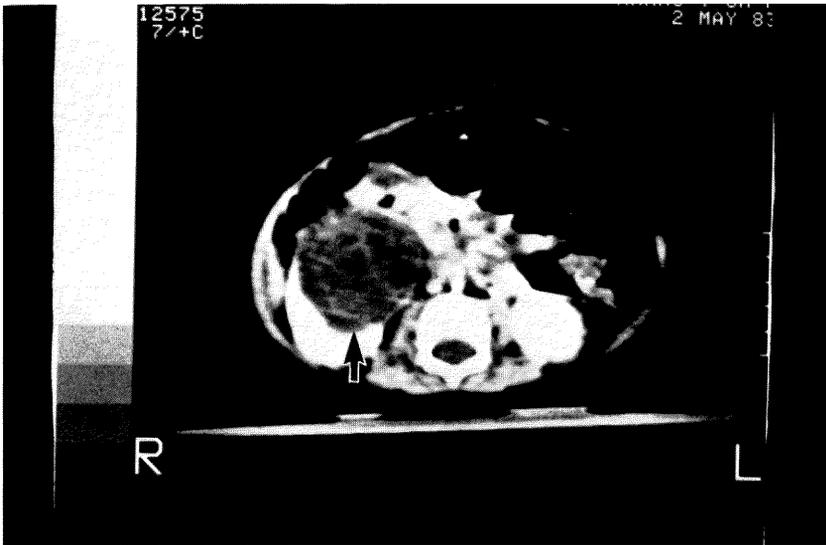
Computerized tomography (CT). CT revealed a well difined mass which contained numerous low density areas irregularly separated by internal septations.
